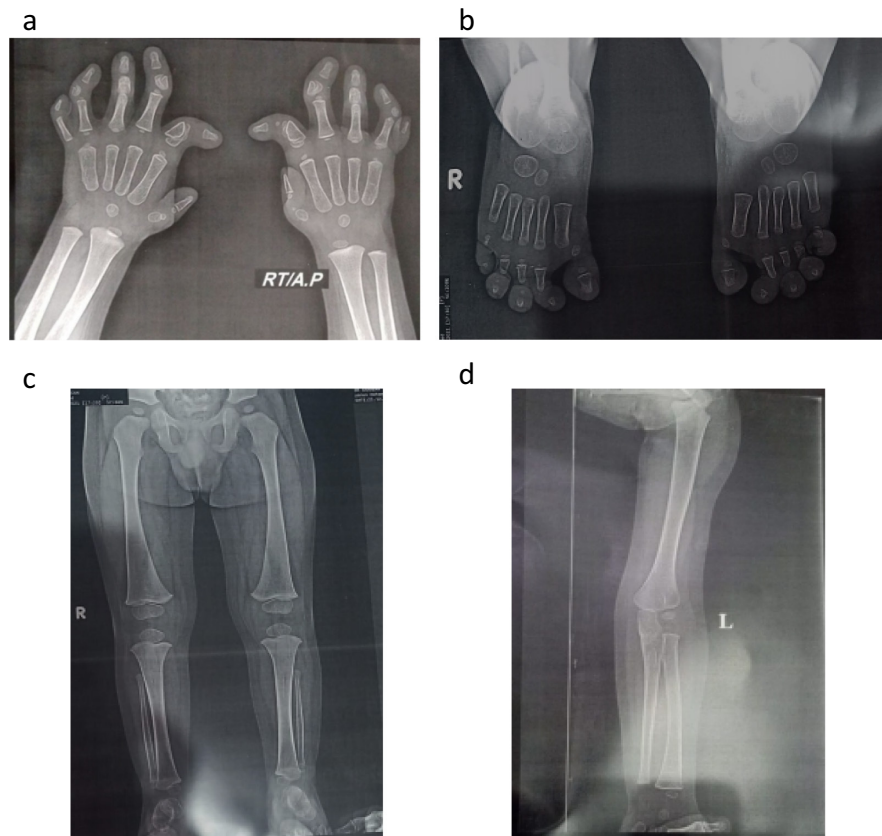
Radiographs of the affected individual. (a) Hands: Abnormalities of metacarpals and phalangeal bones. (b) Feet: Abnormalities of phalangeal bones. (c, d) Lower limbs: Bilateral proximal fibular hypoplasia.
